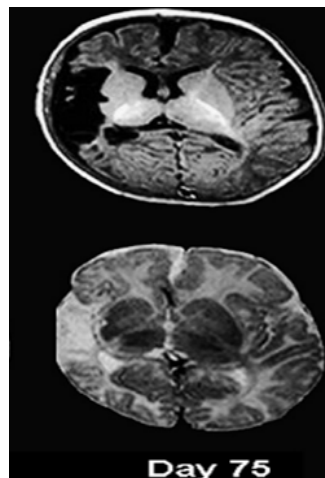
MRI Brain on day 75
